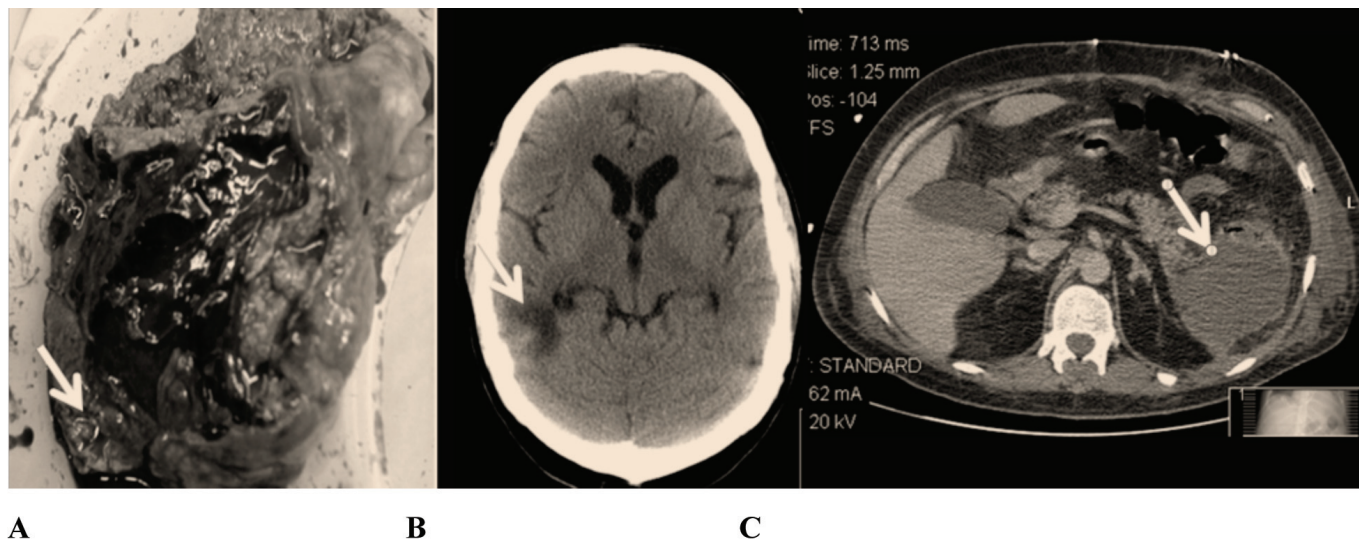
Ruptured spleen (A), a computed tomography (CT) scan of the brain demonstrating a right cerebral abscess (B), and a CT scan of the abdomen demonstrating a collection in the splenic bed following splenectomy (C).
